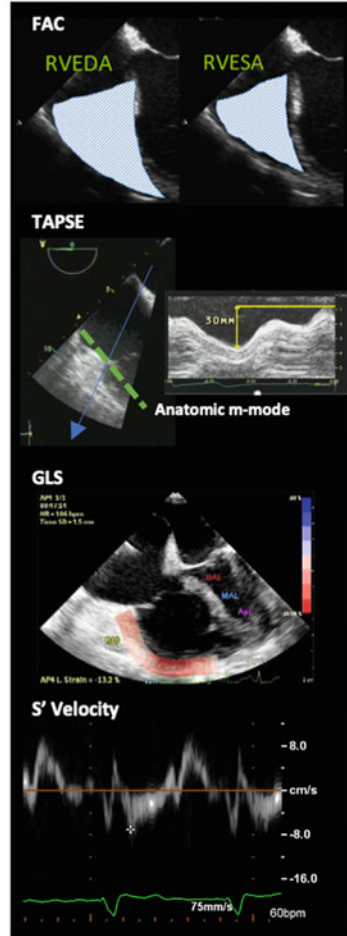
Right Ventricular Function and Size. RV: Right Ventricle; FAC: Fractional Area Change; TAPSE: Tricuspid Valve Annular Plane Systolic Excursion; S': S' Doppler wave; TV: Tricuspid Valve; GLS: Global Lungitudinal Strain; ME: Mid Esophageal; 4C: Four Chambers; EDA: End Diastolic Area; ESA: End Systolic Area; TG: Trans Gastric; LAX: long Axis; TDI: Tissue Doppler
